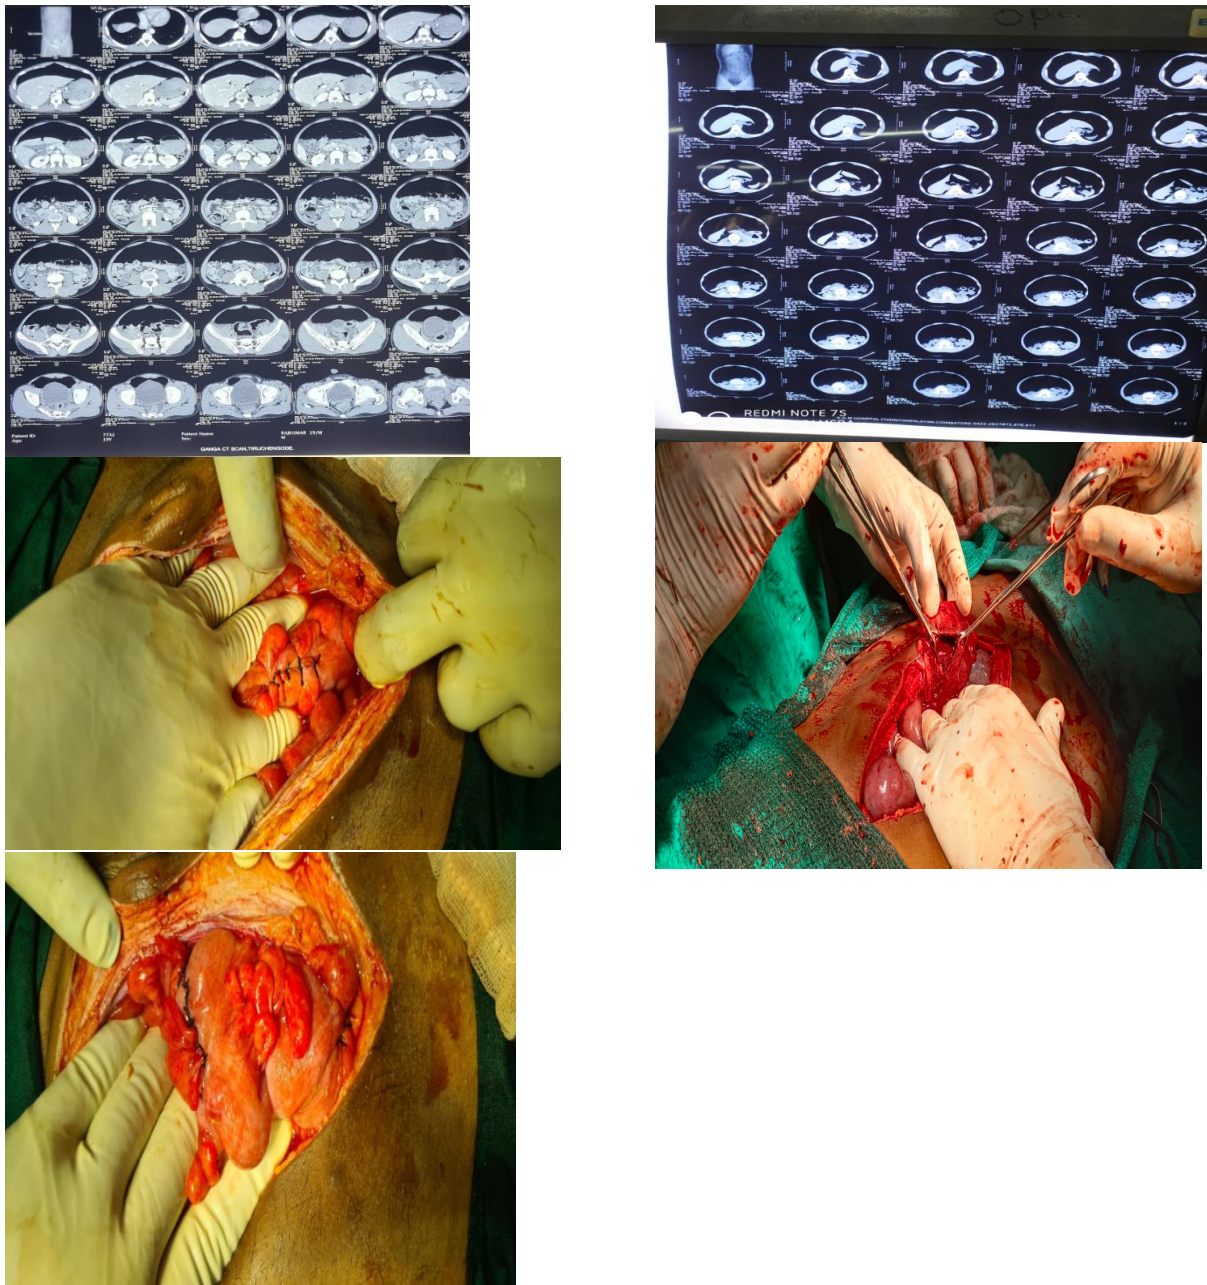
CT image, operating procedure and final wound closure of case report 2
